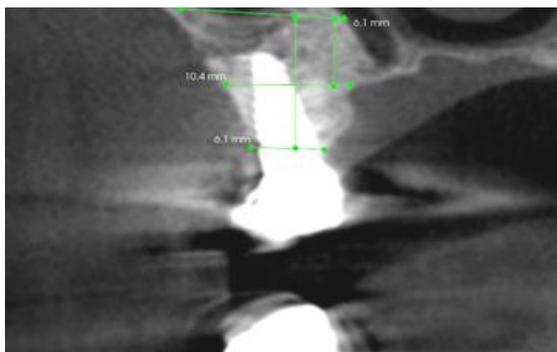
Pre-operative CBCT shows the dimension of the residual bone
